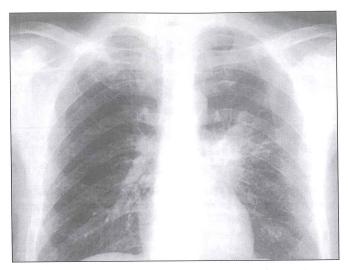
Chest X-ray: A left hilar nodular lesion and a right apical infiltrate.
